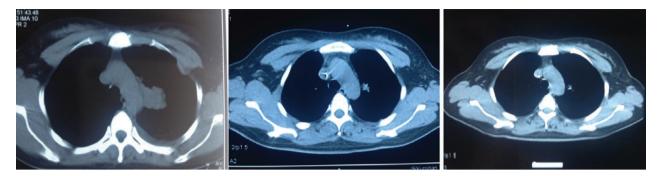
Chest computed tomography scan during six cycles of first-line therapy.
